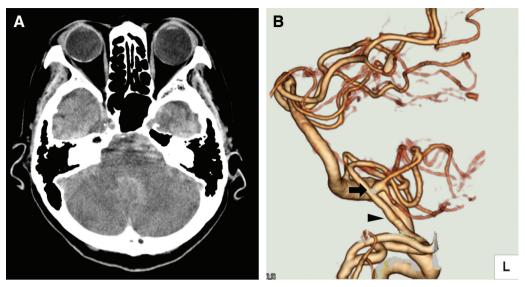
Preoperative CT image and 3D-CTA of the patient. (A) Non-contrast CT depicting SAH in the posterior cranial fossa. (B) 3D-CTA from the left side. The PICA branched from the left VA (arrowhead). The ruptured aneurysm was found at the cortical segment of the left PICA (black arrow). PICA: posterior inferior cerebellar artery; SAH: subarachnoid hemorrhage; VA: vertebral artery
